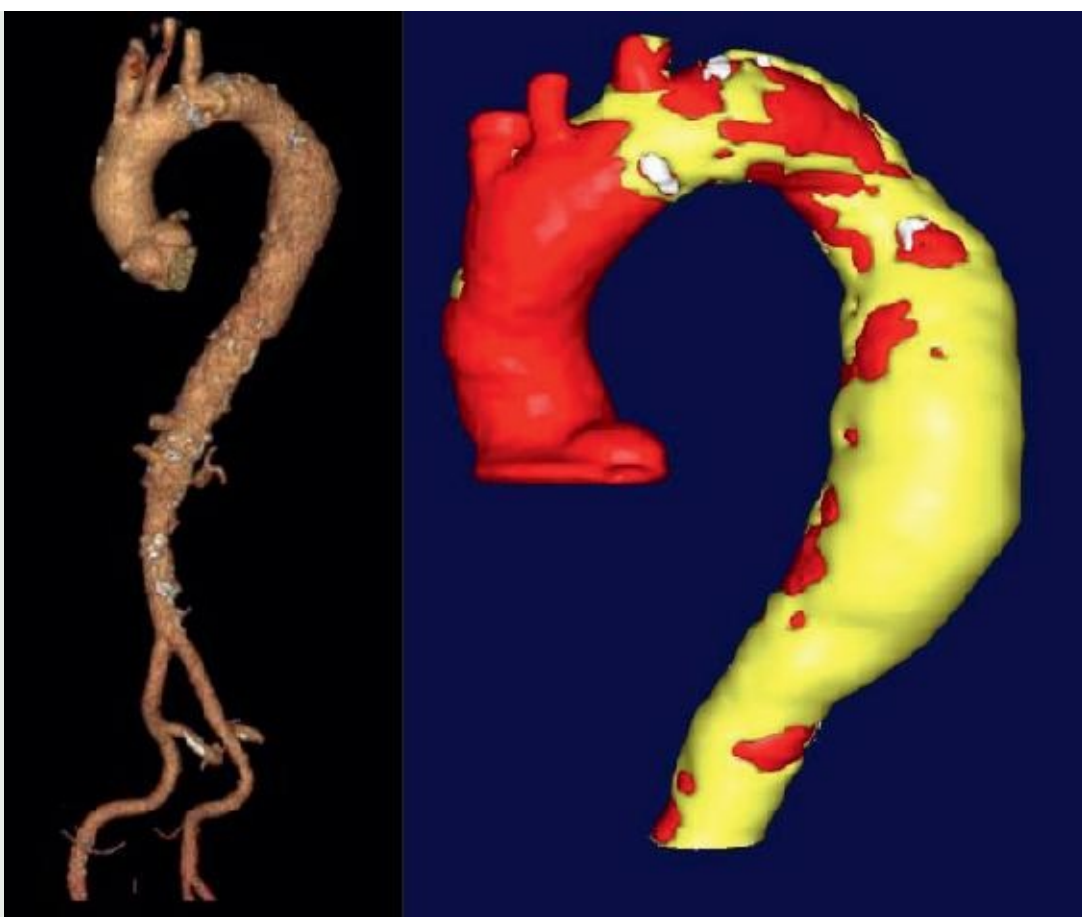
A 73-year old man presented to the ER with symptoms resembling an aortic dissection. CT-imaging revealed a descending aortic aneurysm, measuring 62 mm in diameter. He was evaluated for an elective TEVAR procedure.
